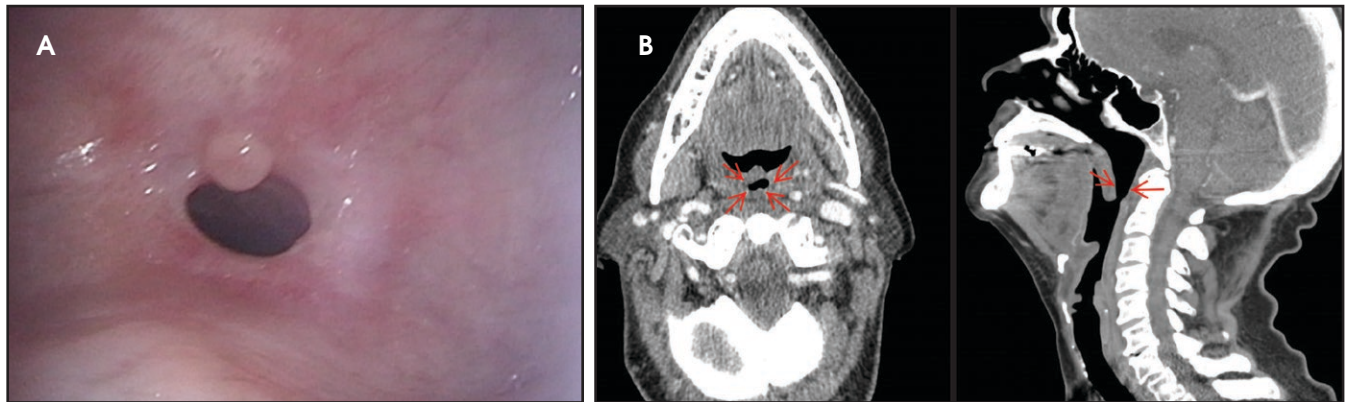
(A) Nasopharyngoscopy demonstrating nasopharyngeal stenosis 9 months after chemoradiation (CRT). (B) Nasopharyngeal stenosis on axial and sagittal neck CT with contrast 10 months after CRT, 1.25-mm scan slice thickness.
